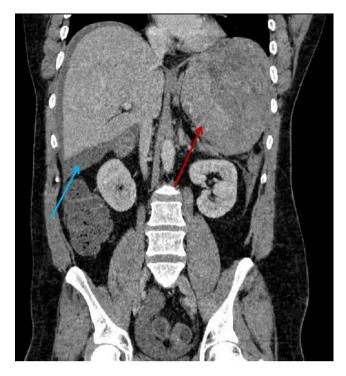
Abdominal contrast-enhanced computed tomography (CT) showing splenic rupture, subcapsular hematoma, and active arterial bleeding (red arrow). Peri-hepatic hemoperitoneum is present (blue arrow)
